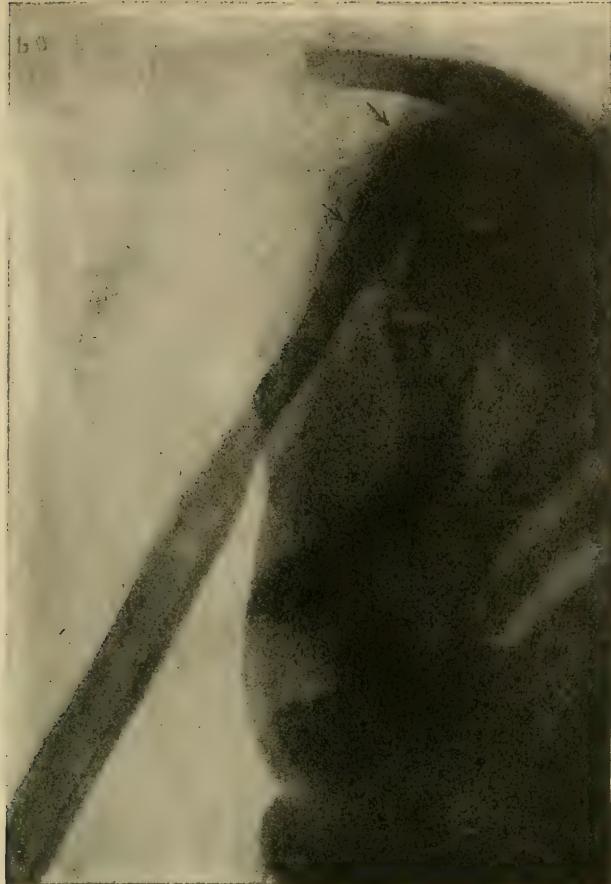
Case 1. Roentgenogram taken four months after bone-graft operation. Note complete bony union of lower end of graft with the humeral shaft and the tendency to cortical fusion. The arrows indicate drill-holes in graft through which muscles were attached by means of fine kangaroo tendon at proper place of insertion. (Albee.)
